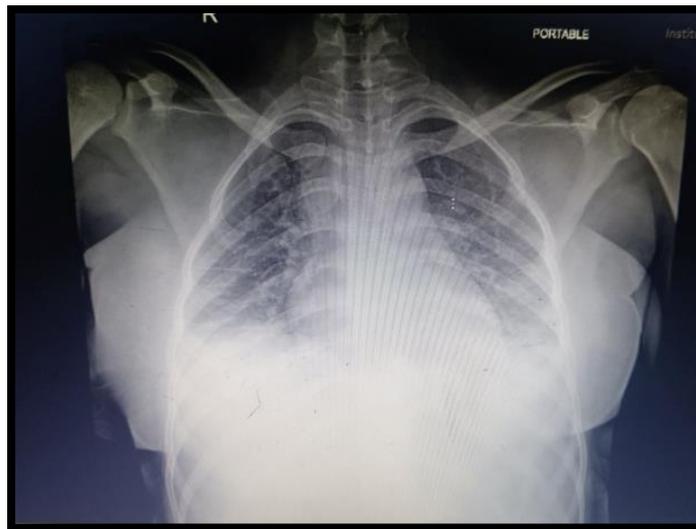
Chest X-Ray – B/L Basal homogenous opacities
